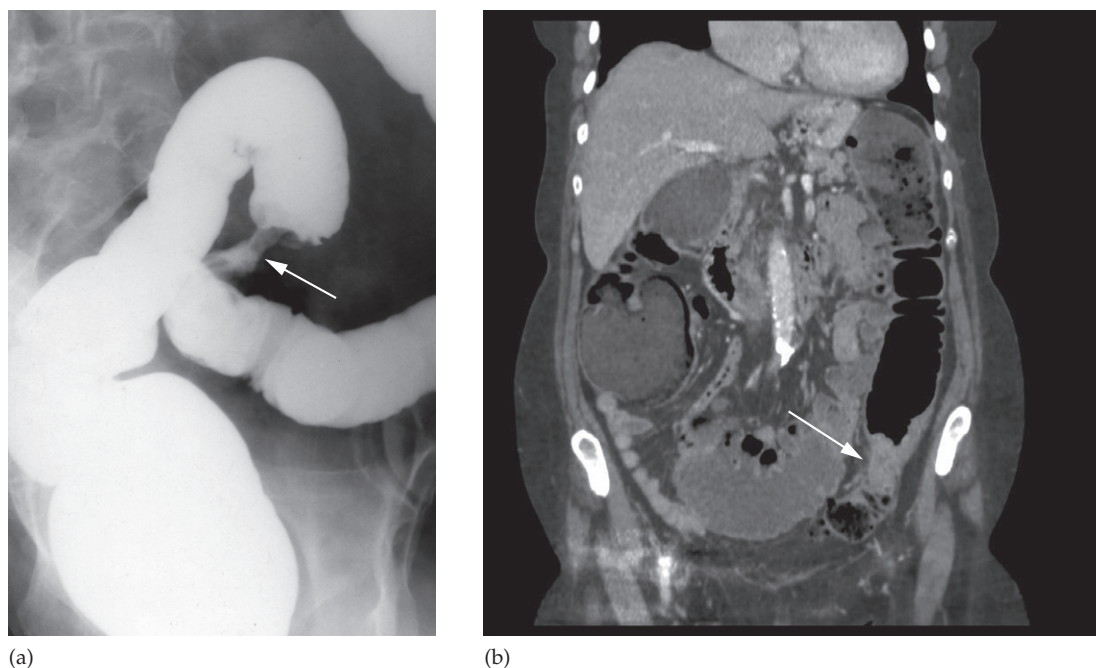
Stricture. (a) Barium enema and (b) coronal CT showing a short, circumferential narrowing in the sigmoid colon (arrows) from a carcinoma.
